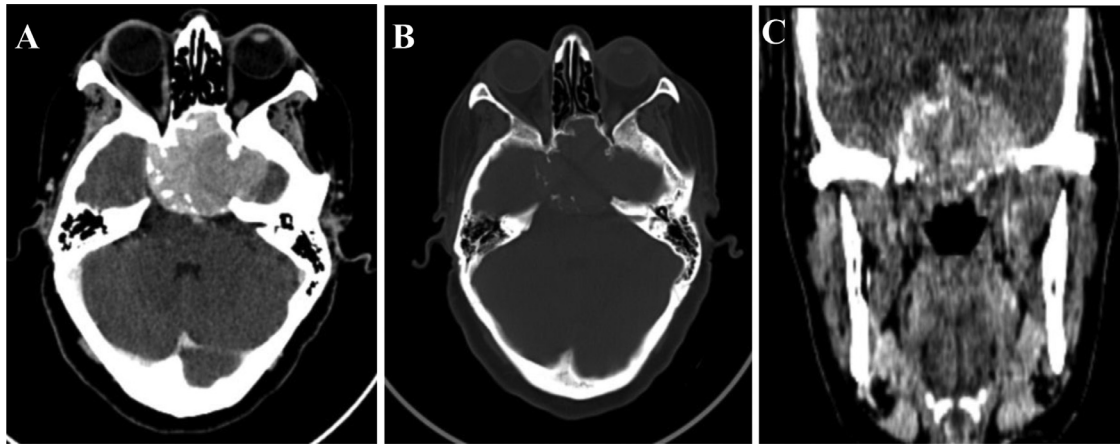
Axial enhanced Brain CT scan (A: Brain window, B: Bone window), (C) Coronal reformation revealing a large expansile and lytic lesion filling the sphenoid sinus with invasion to the adjacent sellar and suprasellar region.
